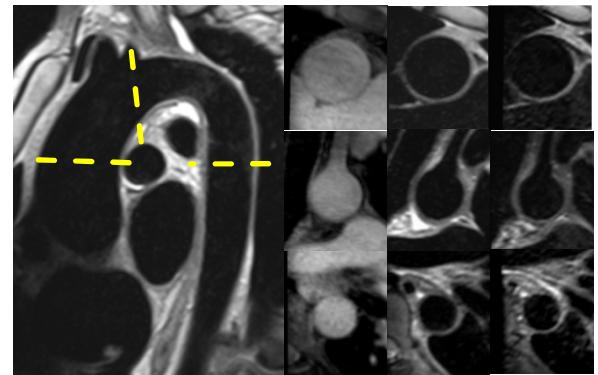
Multi-contrast MRI in 3 representative planes: T1W (first column), T2W (second column), PDW (third column).
